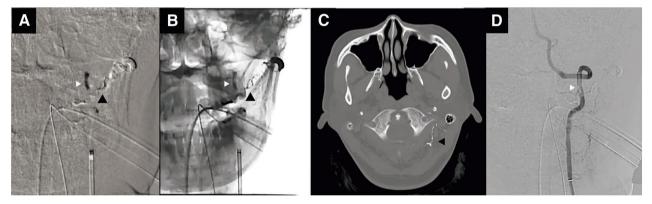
(A and B) Anterior–posterior view of blank roadmap and fluoroscopic images showing the migrated NBCA glue (white arrowheads) to VA through the OA muscle branch (black arrowheads) at the C1 level. (C) Postembolization CT showing the OA muscle branch (black
